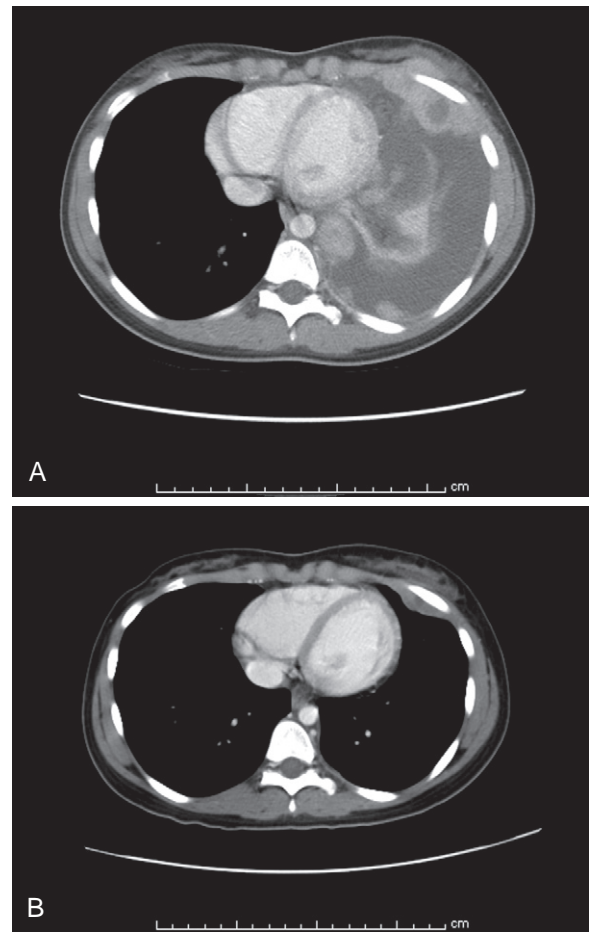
Axial images of a computed tomography scan of the chest in a child with a Ewing sarcoma family/primitive neuroectodermal tumor (EWS/PNET) of the chest wall before (A) and after (B) neoadjuvant chemotherapy.
